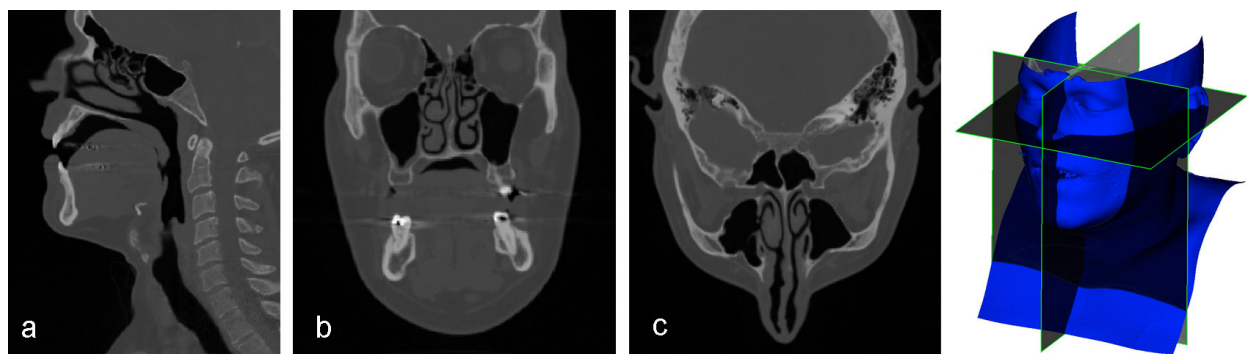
CT scan data set of the upper airways: (a) sagittal view (b) coronal view (c) axial view
